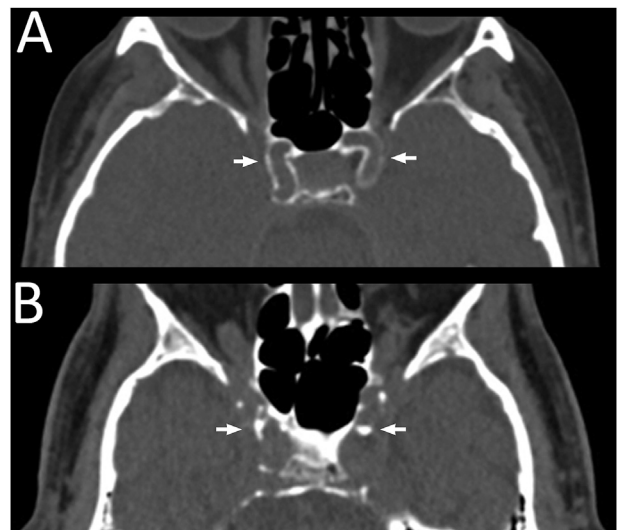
Examples of predominant intimal and predominant medial calcification on CT. (A) An example of predominant medial calcification: a thin continuous line of calcification (arrows). (B) An example of predominant intima calcification: thick dots of calcification (arrows).
